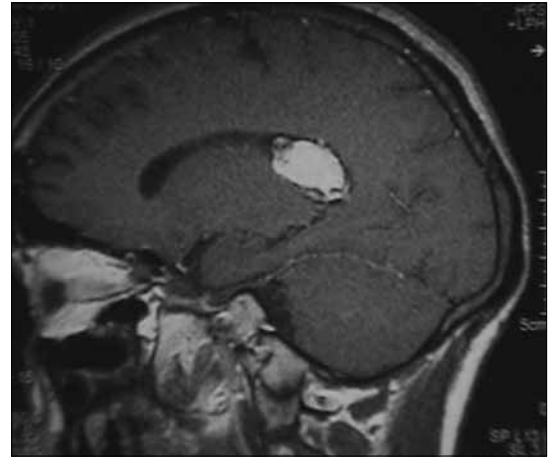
T1-weighted sagittal magnetic resonance imaging scan of the patient showing brilliant contrast enhancement of the lateral ventricular mass
